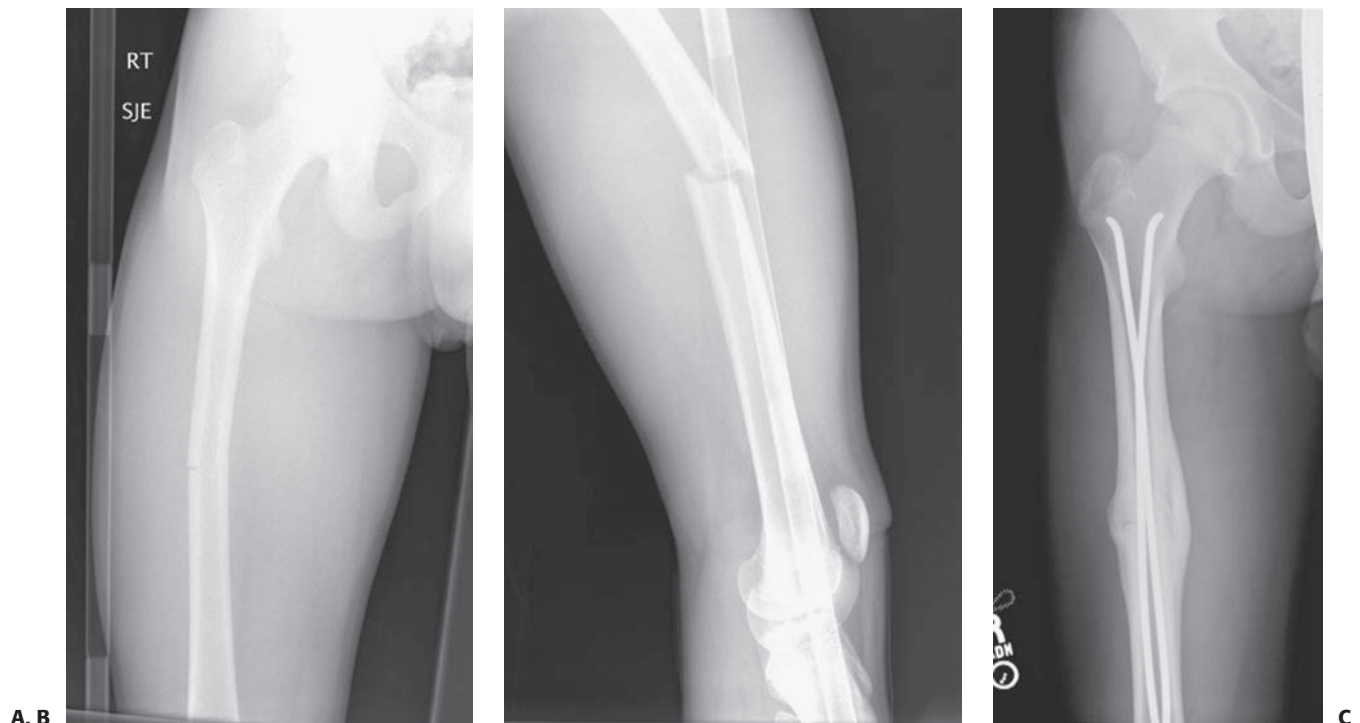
Successful use of titanium elastic nails in older teenager. This 15-year old sustained a minimally displaced midshaft femur fracture A: AP and (B) lateral views at presentation. C: This radiograph, taken 3 months after injury, shows that the fracture healed in perfect alignment with abundant callous.
